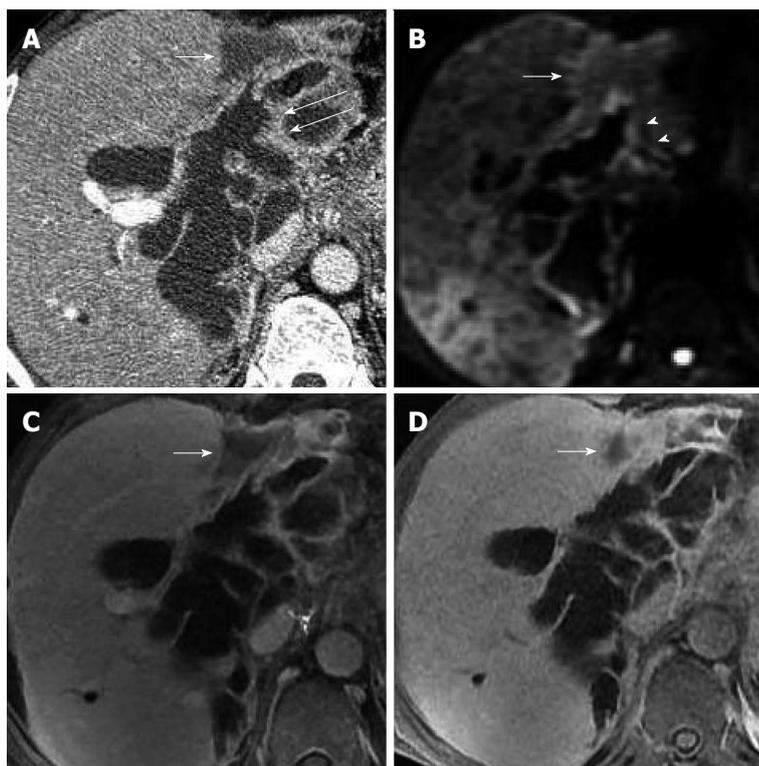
Sixty-six-year-old male patient with malignant intraductal papillary mucinous neoplasm of the bile duct (case 4). A: Axial image of contrast-enhanced computed tomography in the portal venous phase showed a patchy hypointense area abutting the dilated bile ducts in the front edge of the left liver lobe (white arrow), and multiple small nodules distributed along the bile duct wall within the lumen (white long arrows); B: These nodules were hyperintense (white arrowheads) with diffusion-weighted imaging; C: Gadolinium-ethoxybenzyl-diethylenetriamine-pentaacetic acid-enhanced magnetic resonance imaging (Gd-EOB-DTPA-enhanced MRI) in the portal venous phase also showed a patchy hypointense area abutting the dilated bile ducts (white arrow); D: The patch (white arrow) appeared smaller with Gd-EOB-DTPA-enhanced MRI in the hepatobiliary phase, due to the gradual filling of contrast agent, which suggests the presence of functional liver cells. The patchy area was thought to be an inflammatory change secondary to the tumor.
